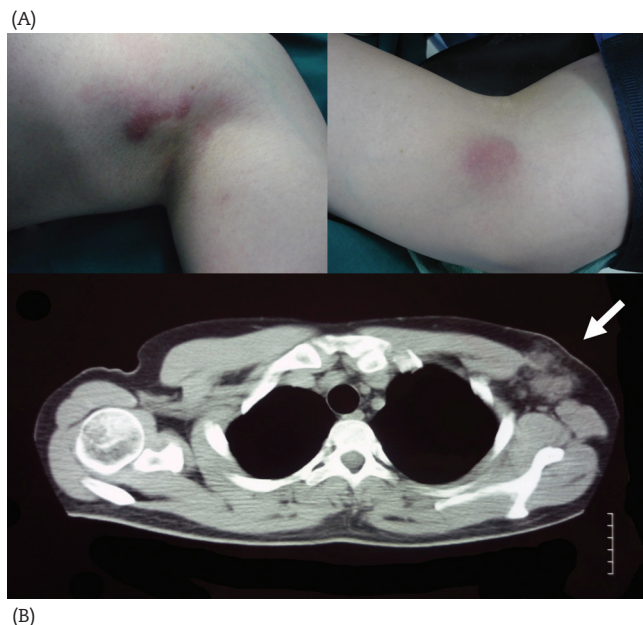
(A) Photograph of the axillary and the left epitrochlear regions, showing the maculopapular erythematous skin rashes. Tender and very painful palpable masses were present at the underlying tissues resembling lymphadenopathy. (B) CT of the axillary region, showing a 4.0 x 3.5 cm soft tissue lesion at the left axilla (arrow), with no signs of abscess formation.
